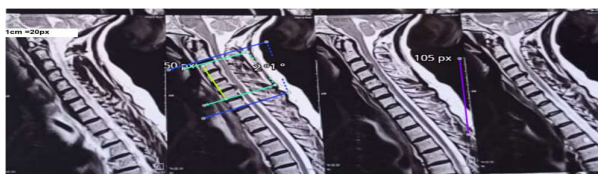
Case 4 Preoperative MRI T2 MRI sagittal view of cervical vertebrae
